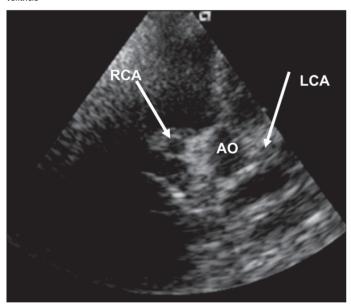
Modified apical five-chamber echocardiographic image: dilated right and left coronary arteries (arrows)
